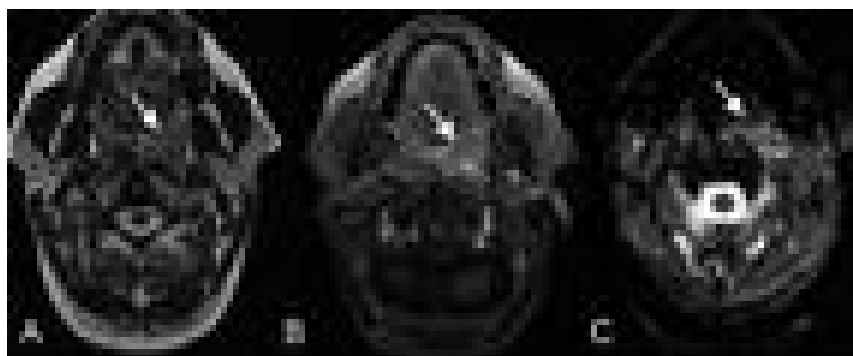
Left tonsil tumor. Conventional MRI (T2 weighted and enhanced T1 acquisitions, respectively A and B), and ADC map (C). Tumor (white arrows) has low signal on ADC map.
